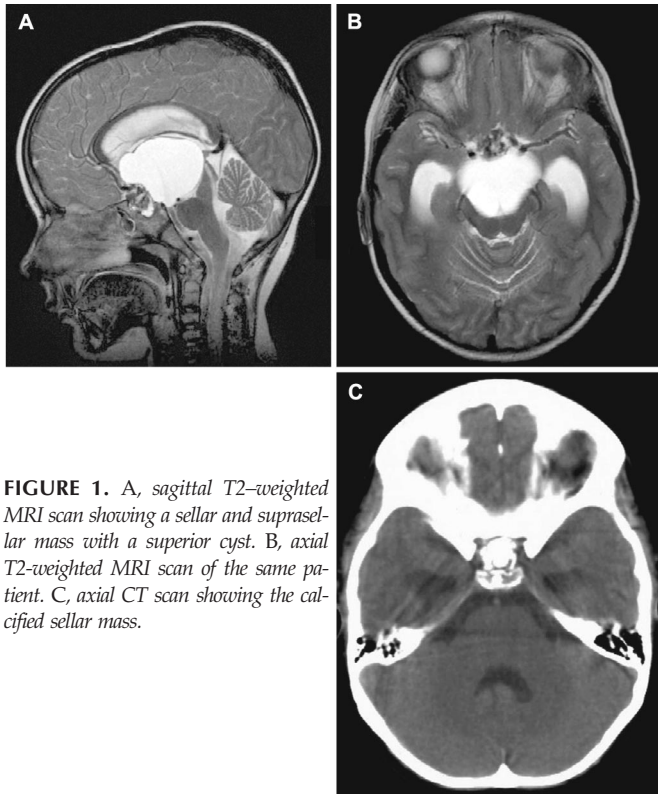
A, sagittal T2-weighted MRI scan showing a sellar and suprasellar mass with a superior cyst. B, axial T2-weighted MRI scan of the same patient. C, axial CT scan showing the calcified sellar mass.
